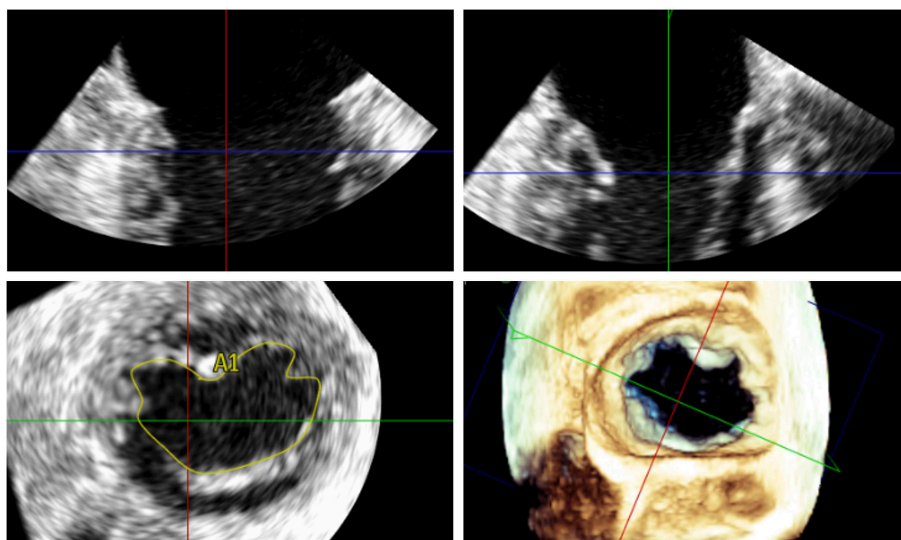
Measurement of the 3D mitral valve area (MVA) by transoesophageal echocardiography in a patient with severe MR; the MVA in this case was 5.48 cm² indicating suitability for percutaneous mitral valve repair.
